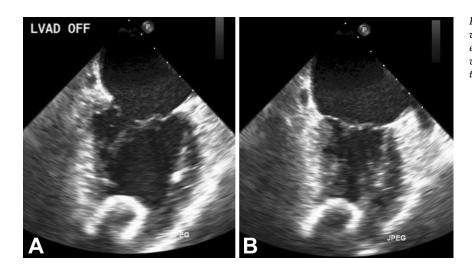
Transesophageal echocardiography with midesophageal two-chamber stills (A) at end diastole and (B) at end systole with left ventricular assist device (LVAD) at 0 rotations per minute (LVAD off).
